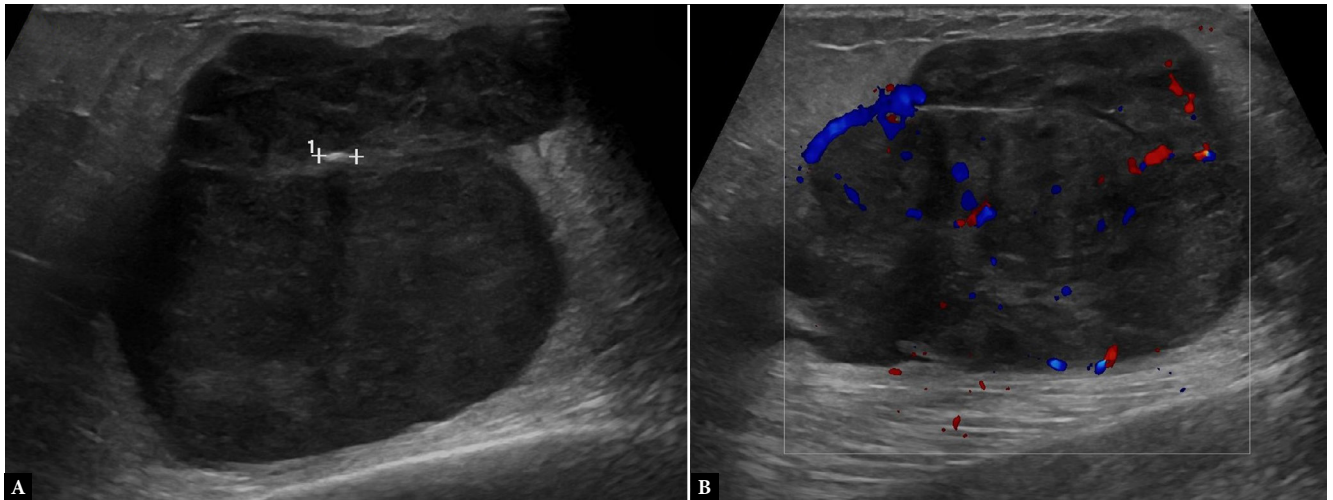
Ultrasound of the medial aspect of the right lower leg showing a large polylobulated subcutaneous mass (5.3 × 4.2 × 7.4 mm) with internal septations and a small calcification (A). CD imaging demonstrates both peripheral and internal vascularity (B), consistent with a soft-tissue sarcoma
